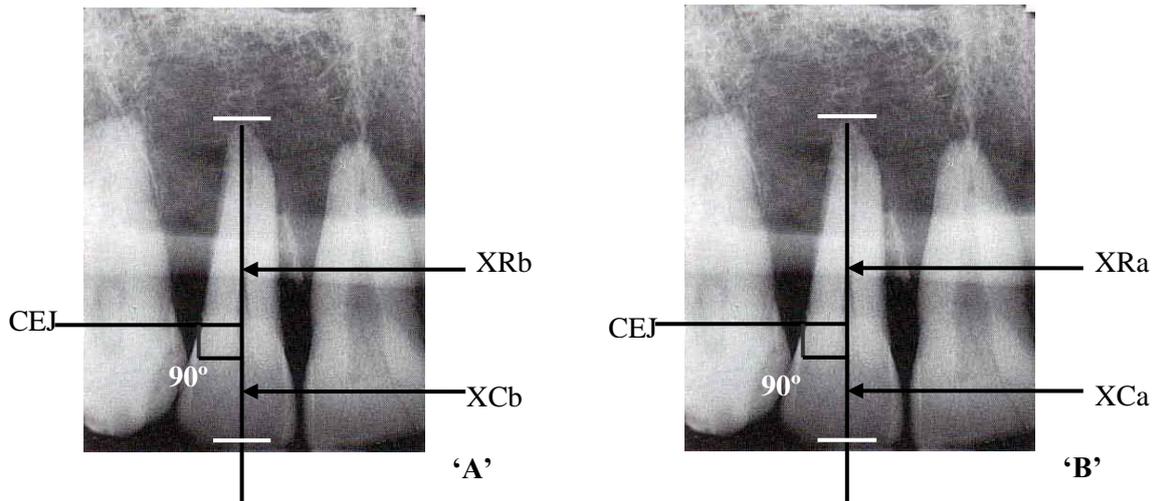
Pre-orthodontic 'A' and post-orthodontic 'B' periapical radiographs taken by paralleling technique
